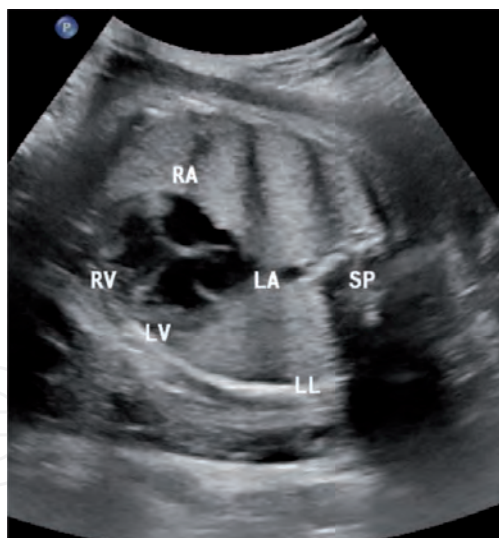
Obstetric ultrasound; 4-chamber heart. Normal four-chamber view of the heart. Transverse scan through the fetal heart showing right ventricle (RV) anteriorly, left ventricle (LV) on the left, right atrium (RA) on the right and the left atrium (LA) as the most posterior. The spine (SP) and left lung (LL) are demonstrated.*
